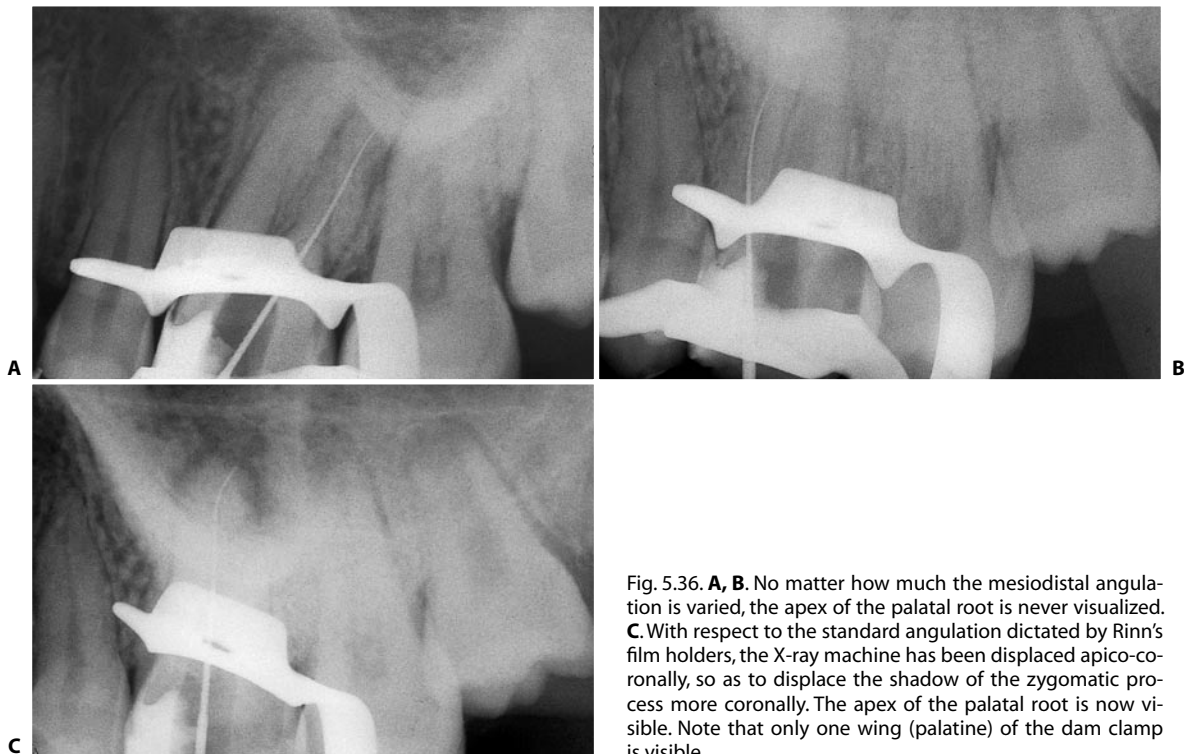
A, B. No matter how much the mesiodistal angulation is varied, the apex of the palatal root is never visualized. C. With respect to the standard angulation dictated by Rinn's film holders, the X-ray machine has been displaced apico-coronally, so as to displace the shadow of the zygomatic process more coronally. The apex of the palatal root is now visible. Note that only one wing (palatine) of the dam clamp is visible.
